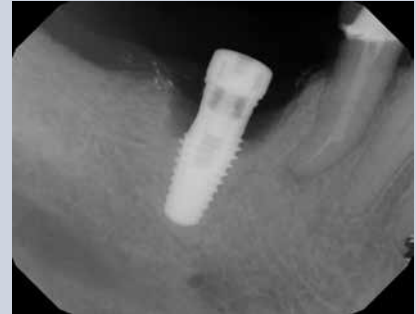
Radiograph of the 46 implant after implantoplasty.
